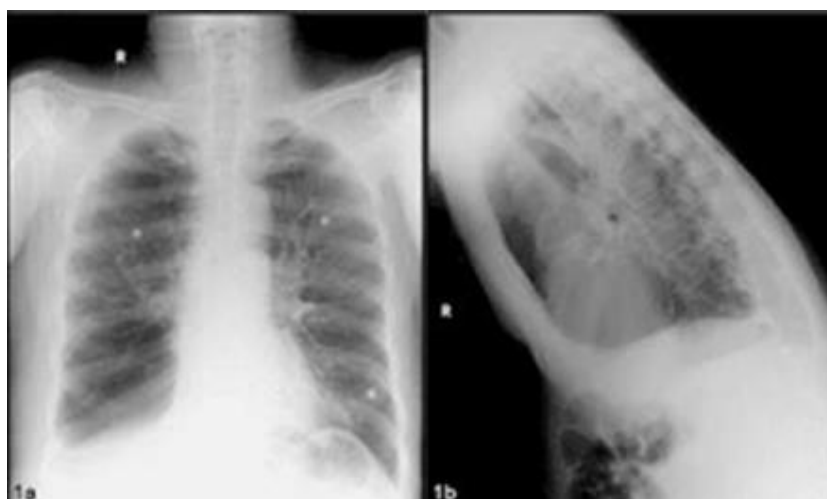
Preoperative (a,b) chest X-rays.
